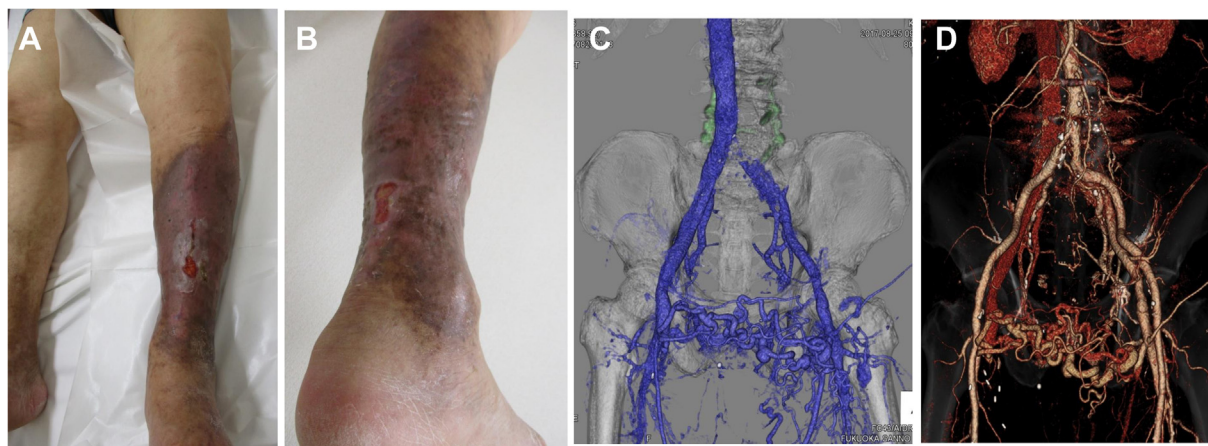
Preoperative clinical data of case 2. A, Stasis ulcer on the anterior tibial region with extensive hyperpigmentation of the left lower extremity. B, Stasis ulcer on the dorsal surface with extensive hyperpigmentation of the left lower extremity. C, Computed tomography (CT) angiography three-dimensional (3D) reconstruction (venous phase) showing occlusion of the left common iliac vein (CIV) with highly developed collateral vessels. D, CT angiography 3D reconstruction (arterial and venous phase) showing early opacification of the left iliac veins. The exact locations of the arteriovenous fistula were not identified.
